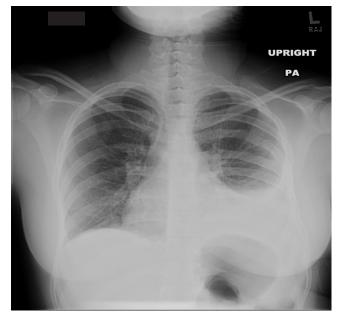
Chest x-ray demonstrating a left-sided pleural effusion.
